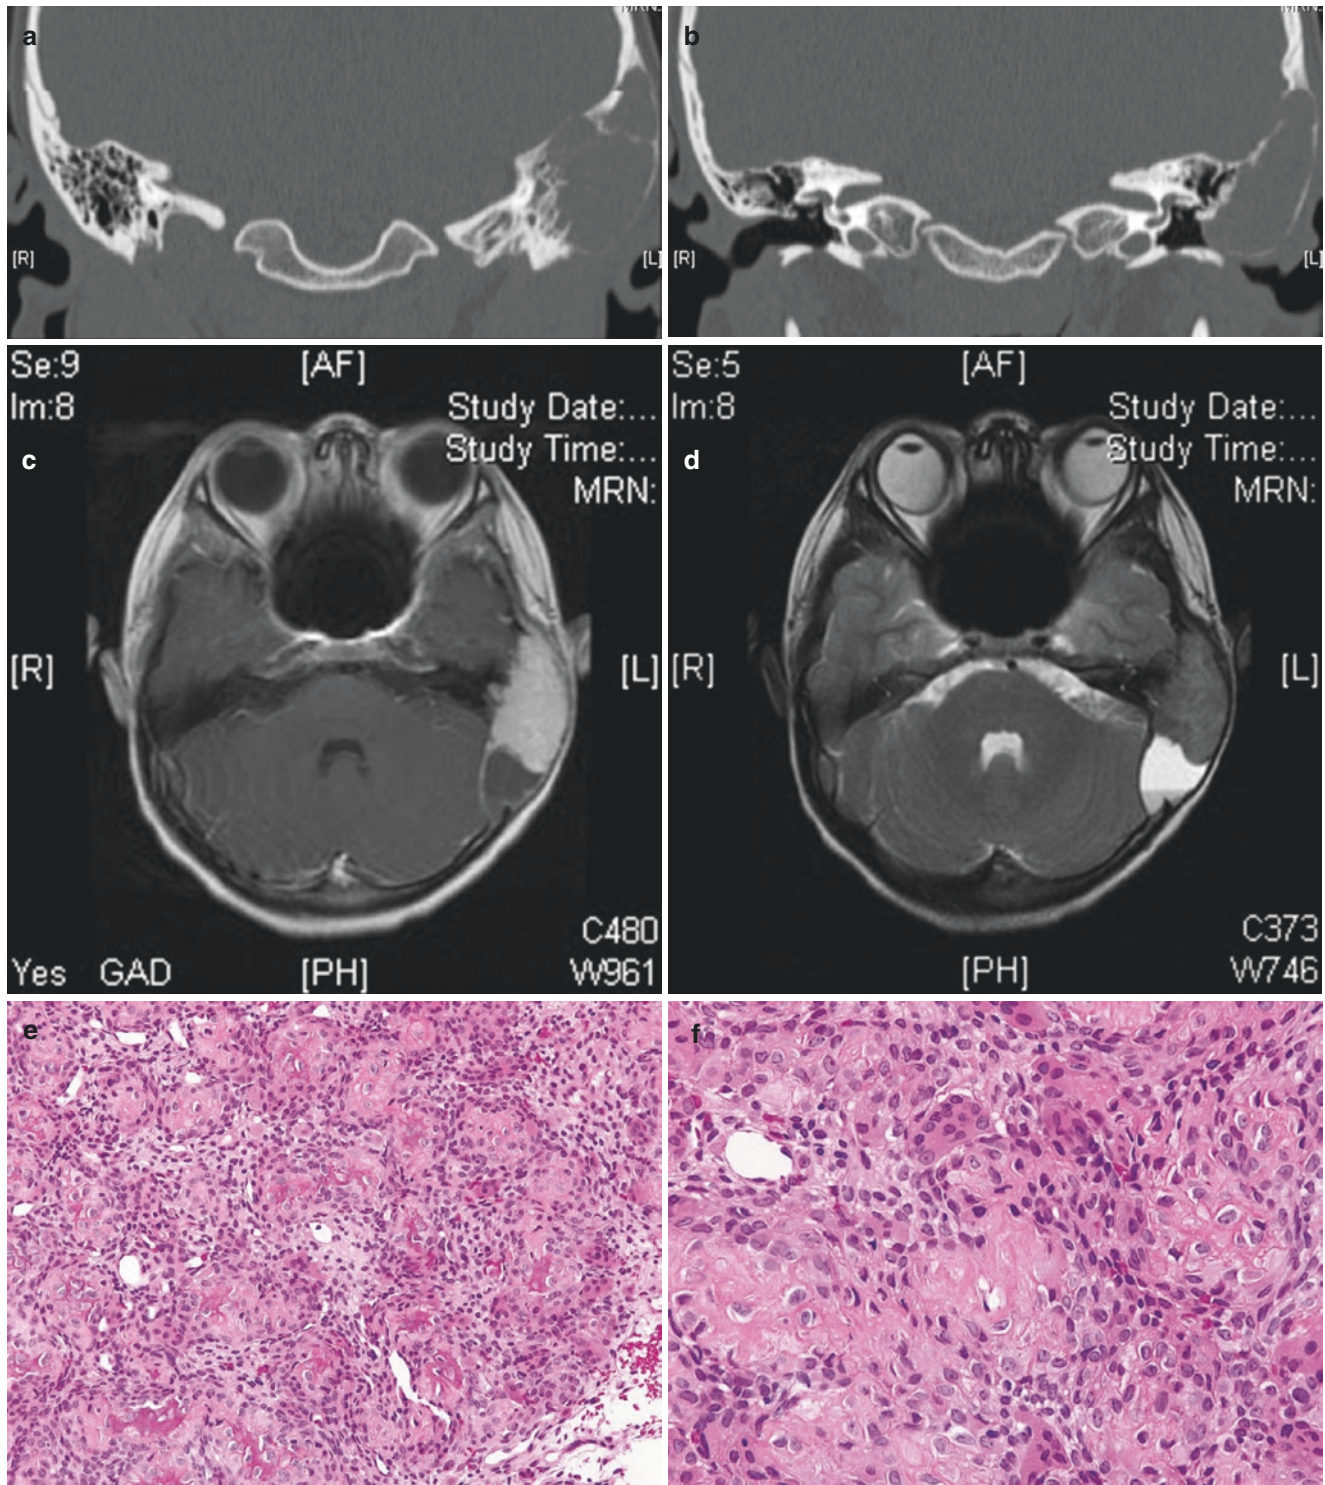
(a) Coronal CT demonstrates an expansive lytic lesion in the mastoid with elevation of periosteum from adjacent cortical bone by the tumor giving rise to a segment of reactive bone known as Codman's triangle superiorly. (b) Coronal CT showing the expansive lytic lesion has occluded the ear canal. (c) Axial T1 MRI with gadolinium showing fluid-filled cyst consistent with an aneurysmal bone cyst within the lesion. (d) Axial T2 frFSE MRI showing fluid-filled cyst consistent with an aneurysmal bone cyst within the lesion. (e) Sections showed a solid bone lesion with crowded irregularly shaped malignant osteoid
